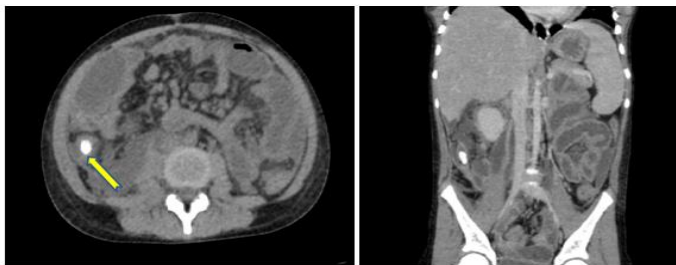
Axial (A) & reconstructed coronal (B) CT images, in 43 years old female patient showing enlarged and enhancing thickened wall of appendix measuring approx. 7.8mm in diameter with a hyperdense solitary intraluminal content of calcific attenuation (mean HU+250), representing an appendicolith associated with hypodense collection in RIF region.
